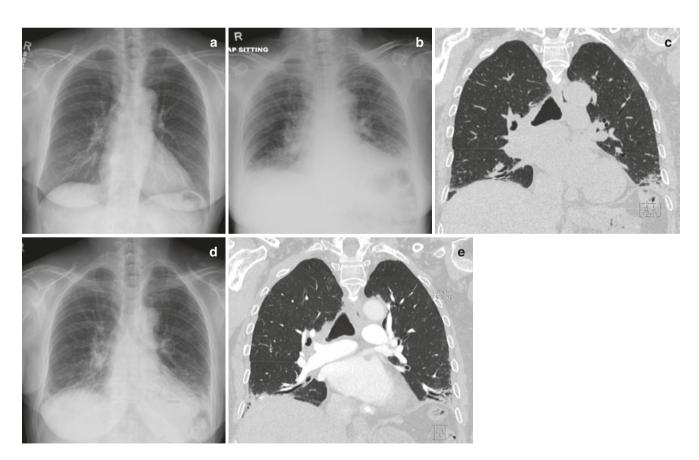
Volume loss in lower lungs in a middle-aged woman with the antisynthetase syndrome. (a) Normal baseline radiograph. (b) Radiograph at presentation shows striking volume loss in lower lungs. (c) Coronal CT image confirms volume loss and bibasilar peribronchial
